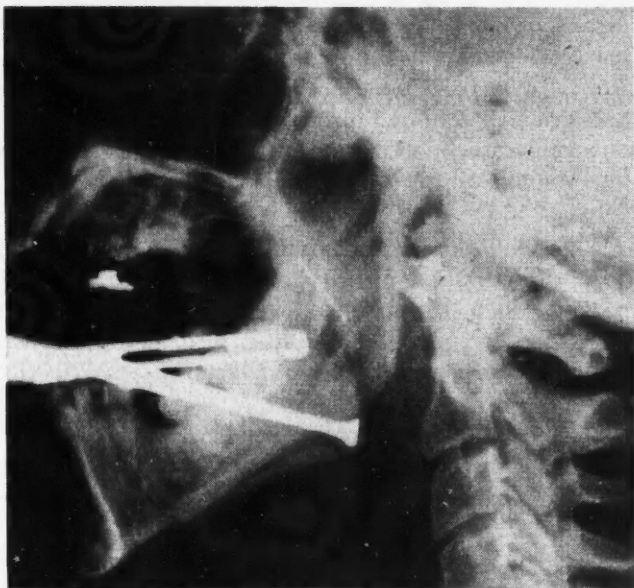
Roentgenogram (lateral view of neck) of same patient showing the broken suture needle in relation to the two Allis forceps inserted in the tonsillar fossa as markers.
